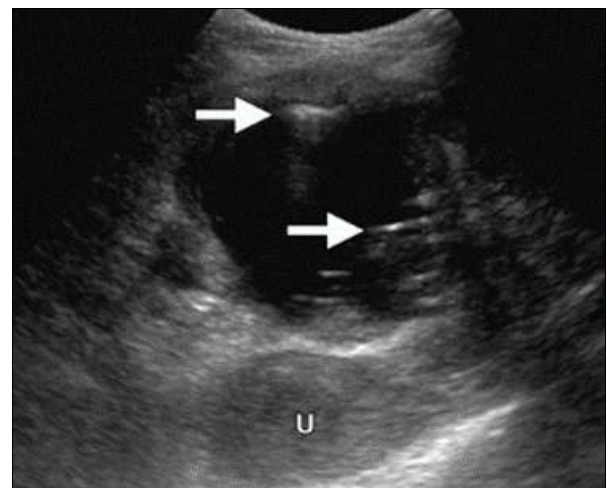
Sonographic finding of Post caesarean uterine scar hematoma
